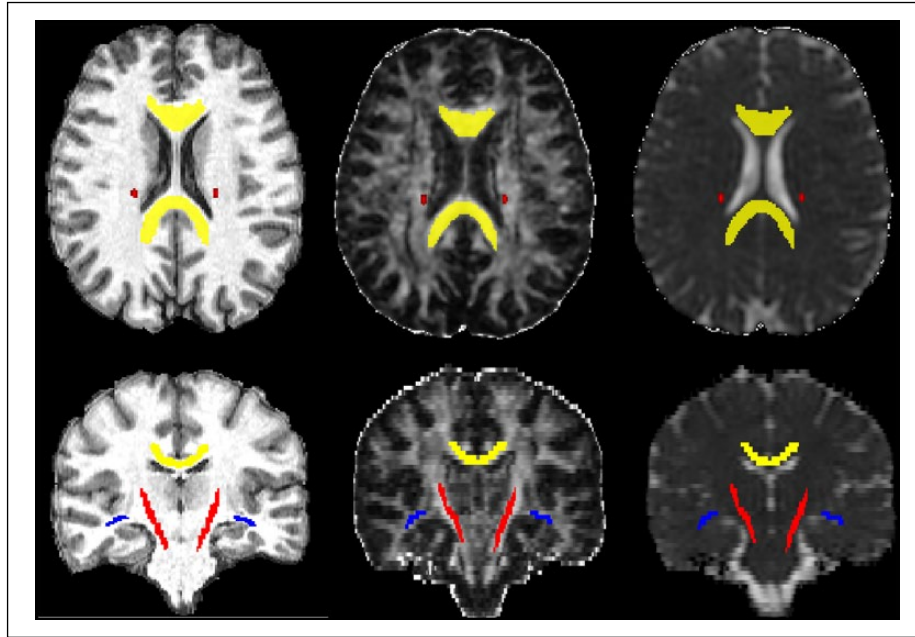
Selected axial (top row) and coronal (bottom row) sections of 3D FSPGR T1-weighted (left column), FA map (middle column), and MD map (right column) images from a CIS patient, with superimposed co-registered JHU atlas masks of CC (yellow), right and left CST (red), and right and left OR (blue).
